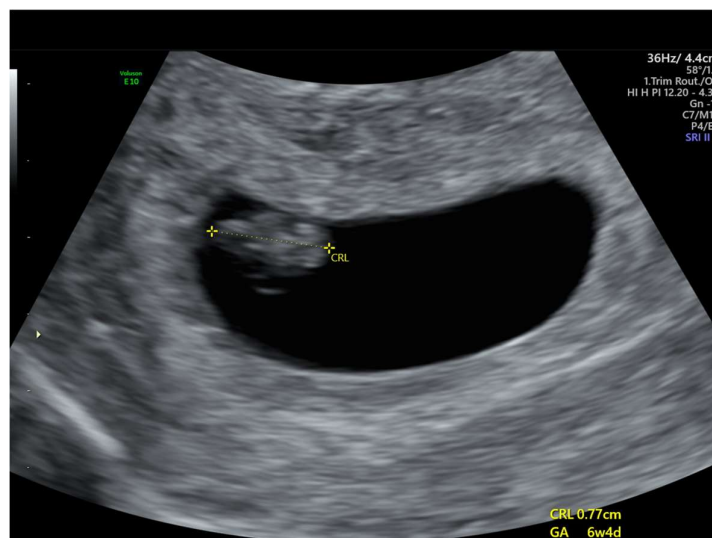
Crown rump length (CRL) measured with contemporary ultrasound equipment. Note electronic 'on screen' calipers and measurements displayed (bottom right corner) with equivalent gestational age. Image produced by D Paoletti.
